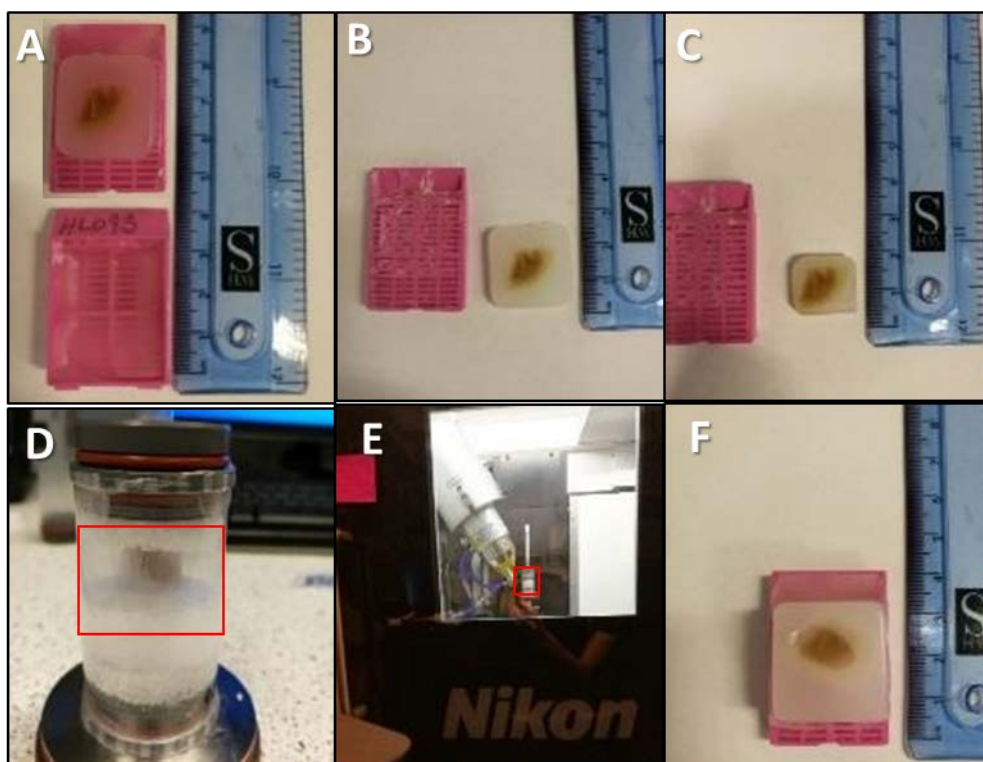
Initial FFPE tissue processing and  $\mu$ CT scanning setup using a custom made holder. A:
